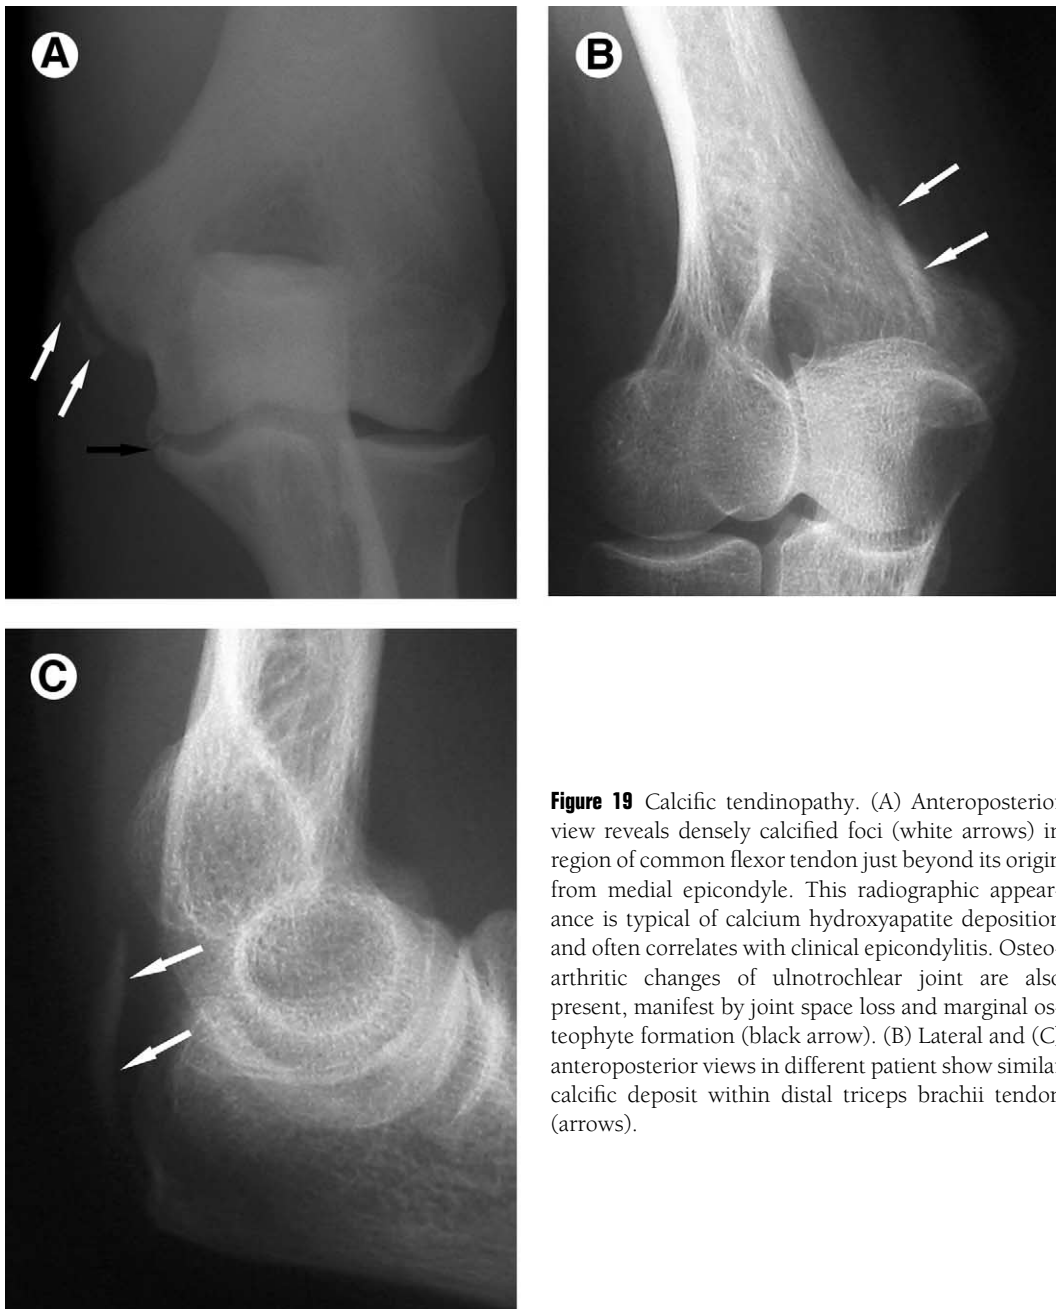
Calcific tendinopathy. (A) Anteroposterior view reveals densely calcified foci (white arrows) in region of common flexor tendon just beyond its origin from medial epicondyle. This radiographic appearance is typical of calcium hydroxyapatite deposition and often correlates with clinical epicondylitis. Osteoarthritic changes of ulnotrochlear joint are also present, manifest by joint space loss and marginal osteophyte formation (black arrow). (B) Lateral and (C) anteroposterior views in different patient show similar calcific deposit within distal triceps brachii tendon (arrows).
